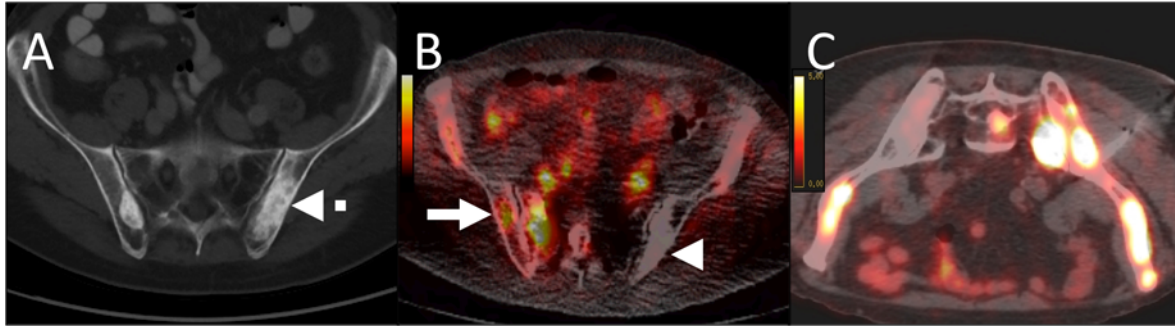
Delayed molecular imaging PET/CT-guided biopsy of a bone metastasis of prostate carcinoma
